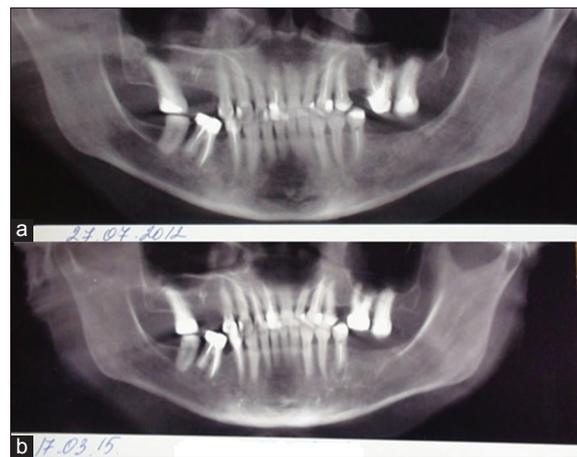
Orthopantomograms of patient D.: (a) - 2012, (b) - 2015. Increased infrared occlusion of 2.6 and 2.7 teeth
